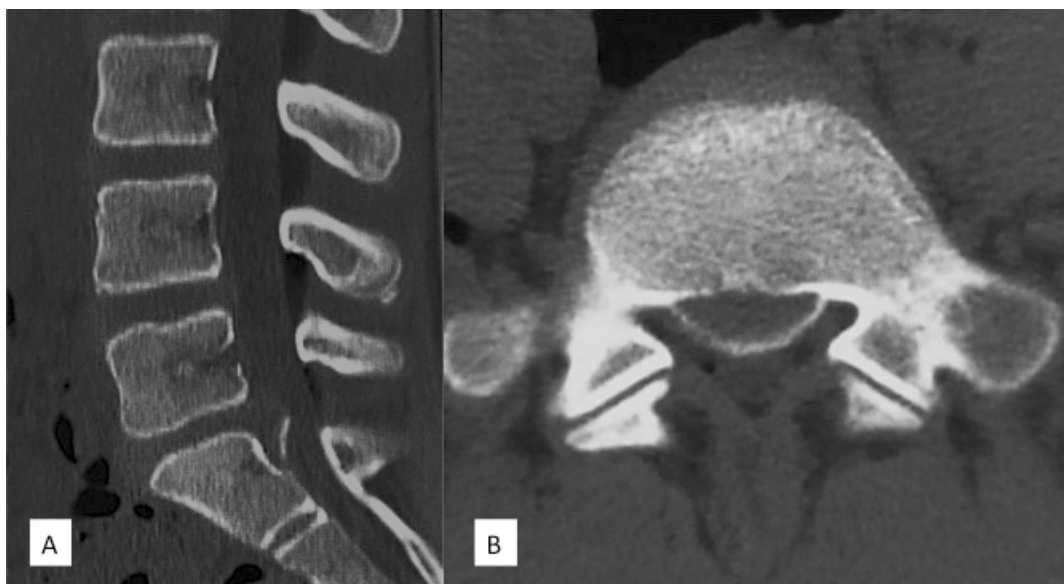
Sagittal (A) and axial (B) reconstructed CT scans showing the fractured apophyseal ring of the superior endplate of S1
